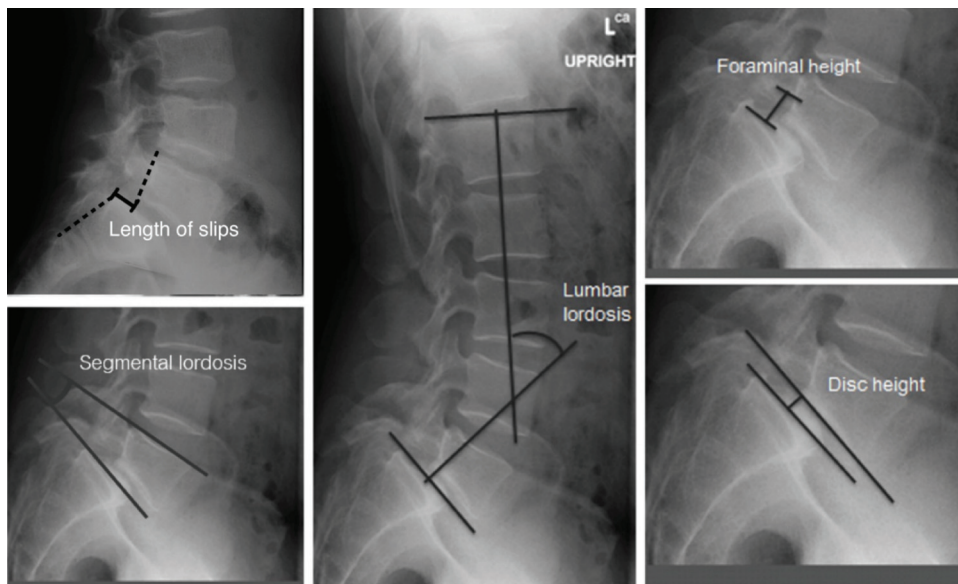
Lateral preoperative radiographs demonstrating measurement of the length of slips, lumbar lordosis, segmental lordosis, foraminal height and disc height.
